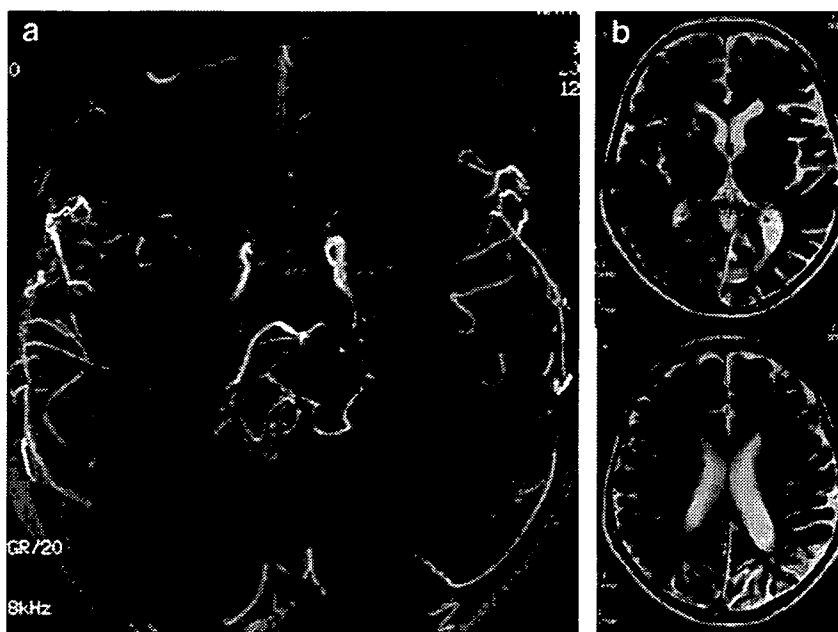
Case 2. Postoperative MRA 1 year after surgery (a) demonstrating the patent STA–MCA bypasses and significant development of pial synangiosis bilaterally. Postoperative T2-weighted images (b) showed no change on both hemispheres compared to pre-operative finding
